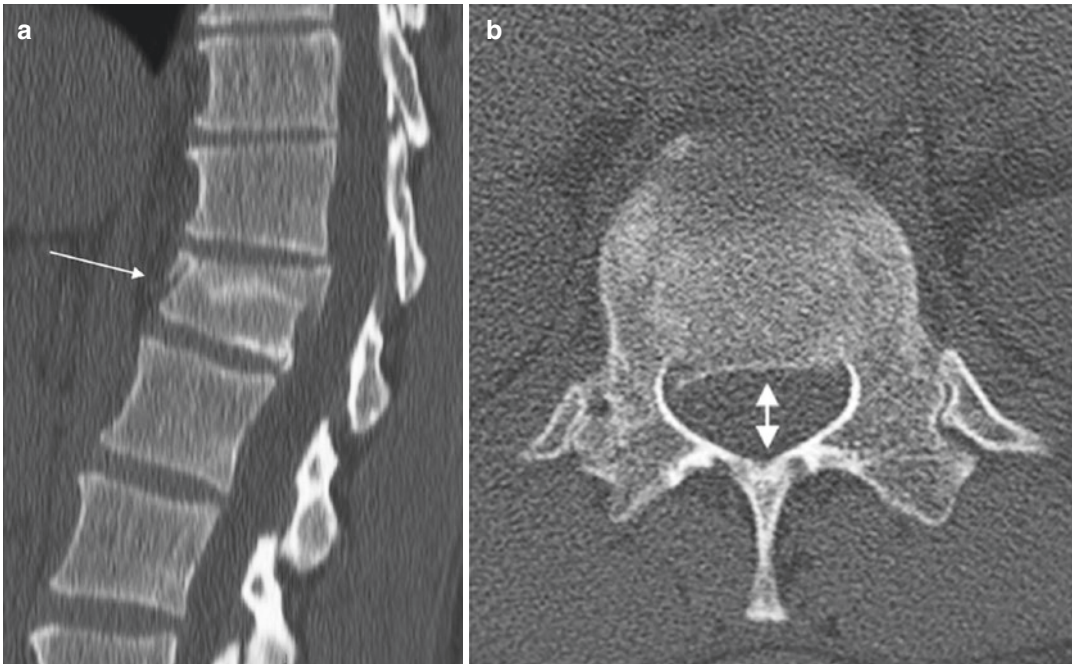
Sagittal (a) and axial (b) CT images of a T12 burst fracture in a patient who fell three metres. There is loss of vertebral body height (<50%), minimal retropulsion (<50%) and spinal canal narrowing (double arrow).
